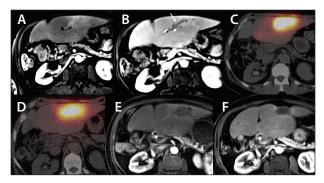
Pretreatment, intrahepatic left portal vein thrombosis (arrow) with subtle arterial enhancement and washout, measuring 8.4 X 3.2 cm, within the vein as well as the geographic area of segment 3, consistent with HCC (A, B). Tc99m MAA SPECT/CT confirmed the complete coverage of the targeted tumor within segment 2 and absence of extrahepatic activity (C). Y-90 bremsstrahlung SPECT/CT confirmed the complete coverage of the targeted tumor within segment 3 and absence of extrahepatic activity (D). Posttreatment MRI arterial phase images at 6 weeks and 7 months, respectively, demonstrated complete response without recurrence of disease (E, F).
